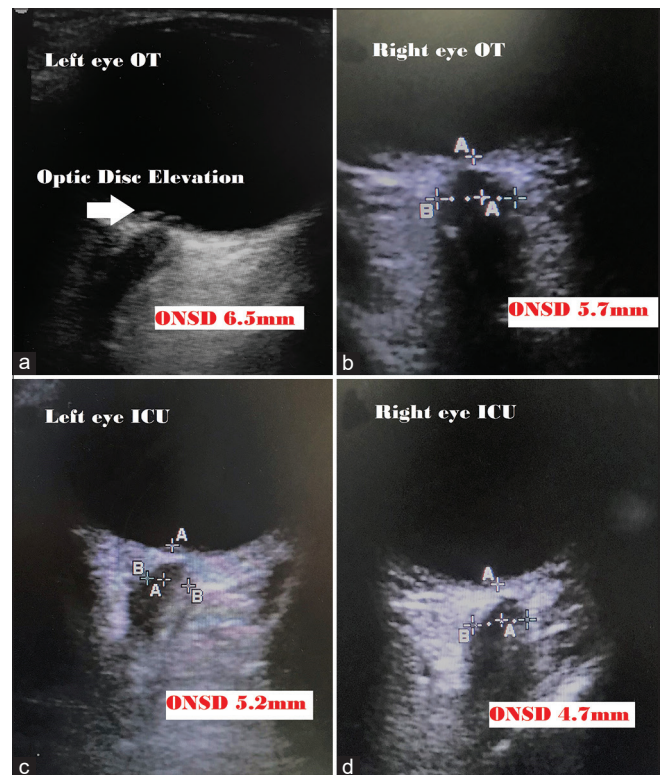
(Arrow in figure 1a- Papilledema) Point-of-care ultrasound showing changes between OT (a,b) and ICU (c,d) measurement. Point A – 3 mm behind the globe. Point B – optic nerve sheath diameter.
